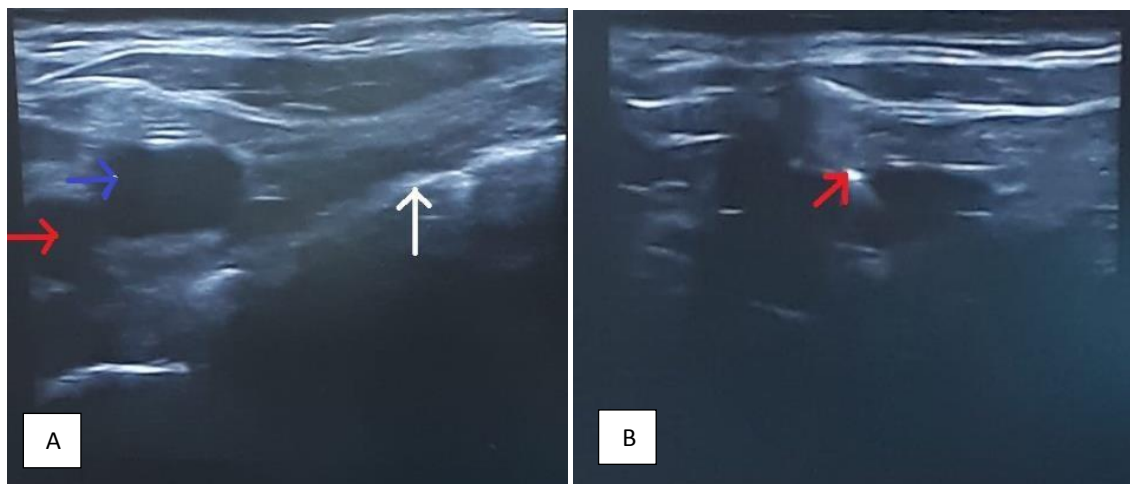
A: Ultrasound image showing the administration of the out-of-plane technique (blue arrow: subclavian vein, red arrow: subclavian artery, white arrow: pleura), B: The out-of-plane technique (the white area pointed by the red arrow shows the needle insertion point)
